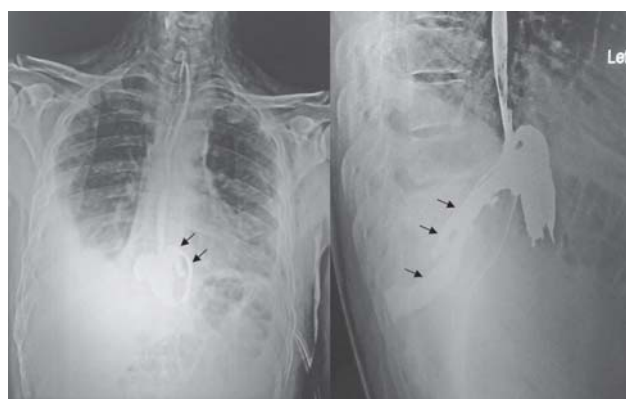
Radiograph barium swallow (PA and lateral views) showing abnormal extravasations of the contrast into pleural space (arrows).
